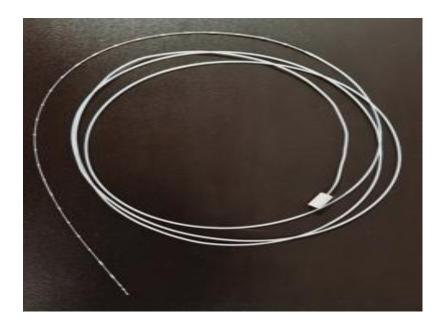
showing a Dummy source cable used at the time of CT scan
